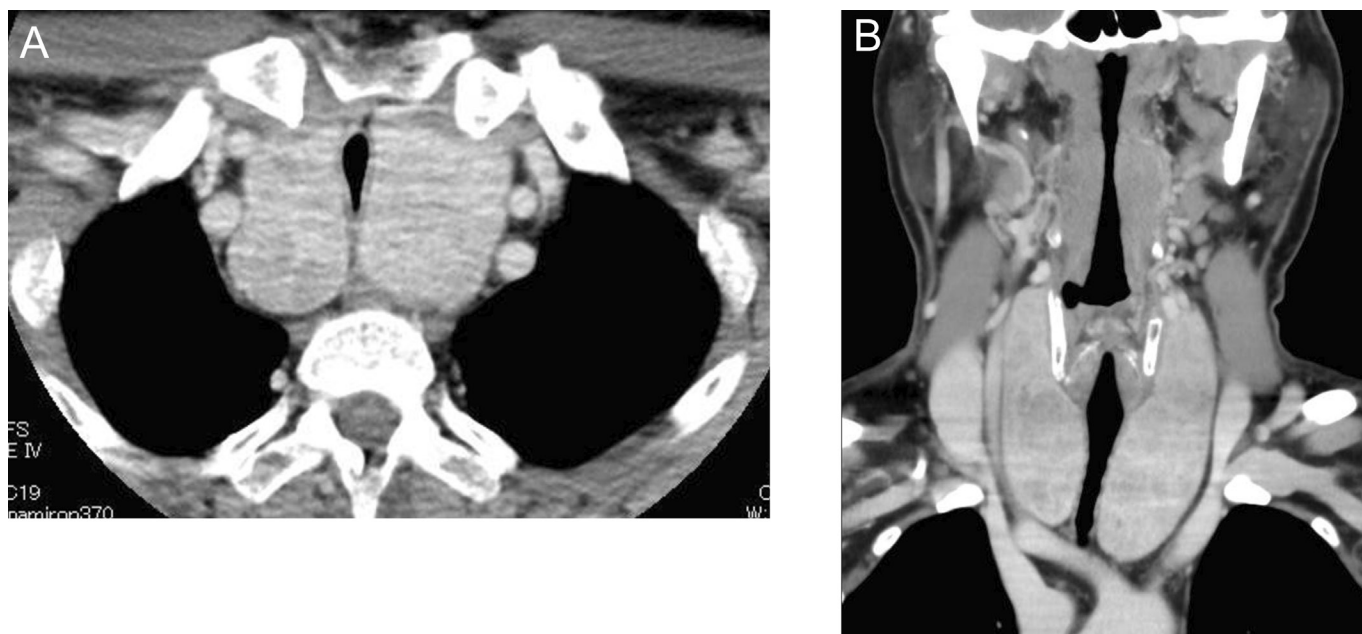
CT findings. (A) Axial view. (B) Coronal view.
